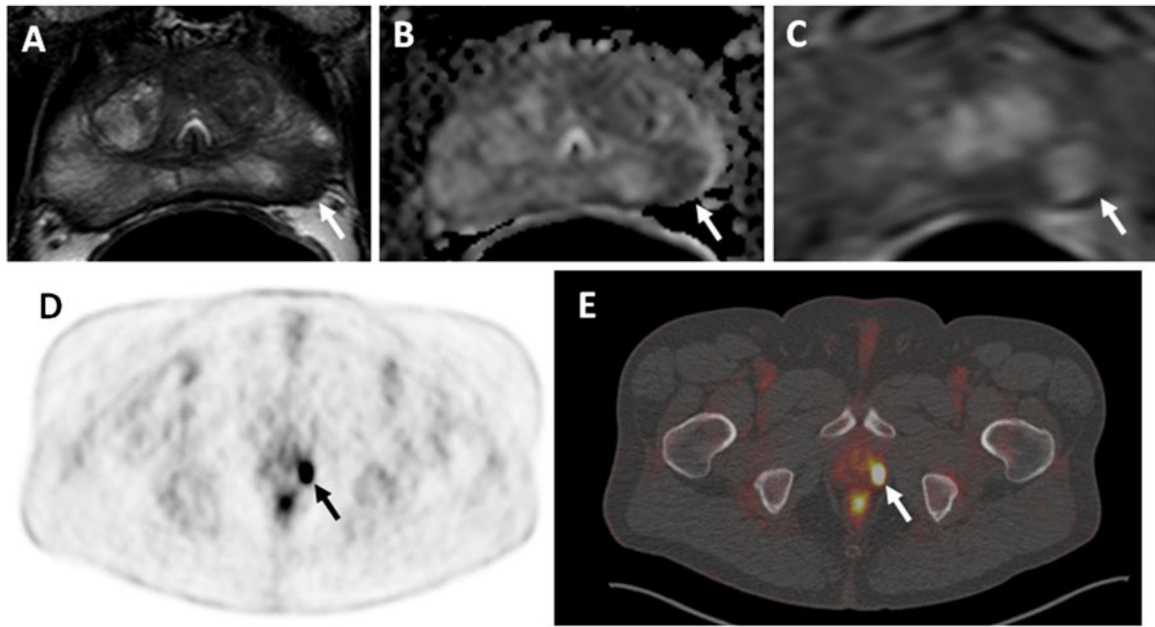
A 63-year-old man with a PSA 7 ng/ml. Axial T2-W MR image (a), ADC map of DW MRI (b) and raw DCE MR image (c) demonstrate a lesion in the left apical PZ (arrows). Significant uptake of ^{18}F -FDG (arrows) is seen in the left-sided lesion in the PET image (d) and the hybrid PET/CT image (e). Subsequent transrectal ultrasonography/MRI fusion-guided biopsy revealed a Gleason 3+4 tumor in the left apical PZ lesion
